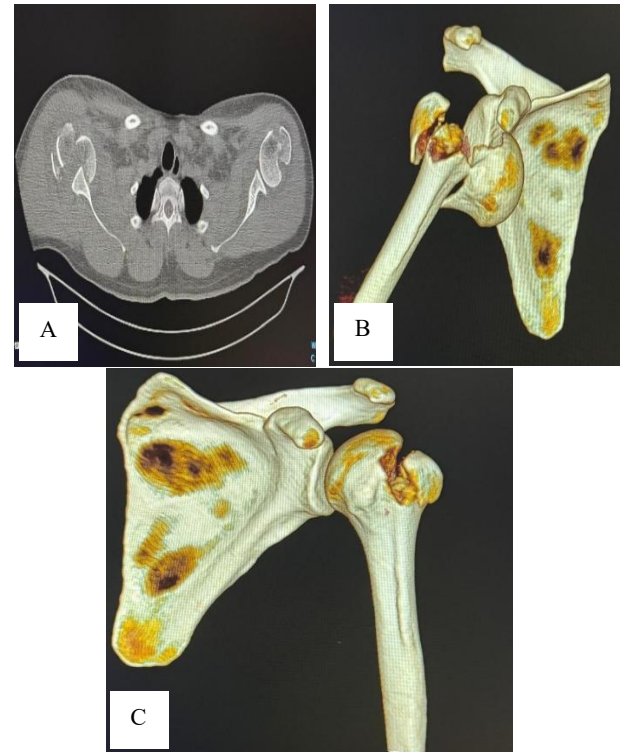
(A-C): Pre-op 3D CT images showing bilateral comminuted proximal humerus fractures with anterior dislocation.
